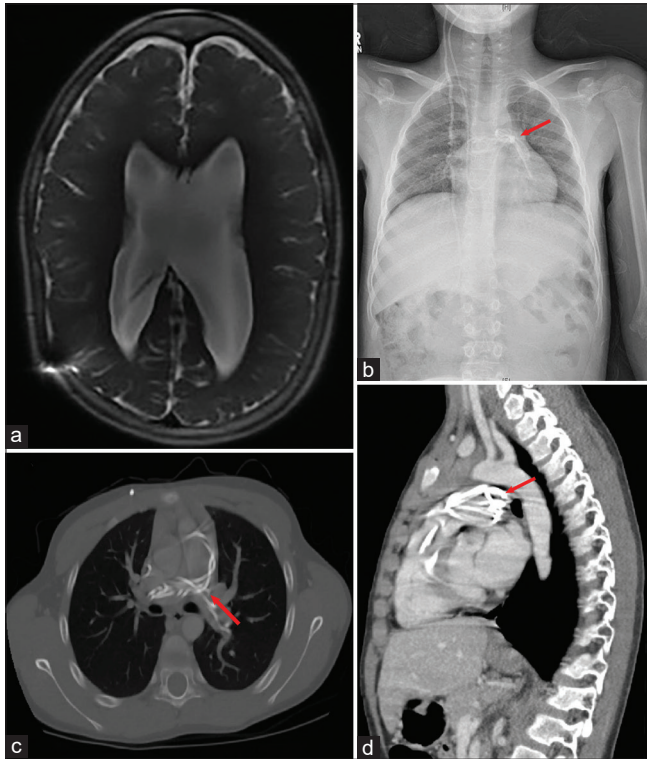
T2 MRI axial views with contrast revealed ventriculomegaly (a). X-ray shunt series demonstrated migration of the distal VP shunt catheter into the heart and pulmonary artery, with evidence of intracardiac knotting (red arrow) (b). Noncontrast chest CT in the axial and sagittal views showed extensive knotting of the distal shunt catheter in the pulmonary vasculature (arrow) without definite arterial thrombosis (c and d).
